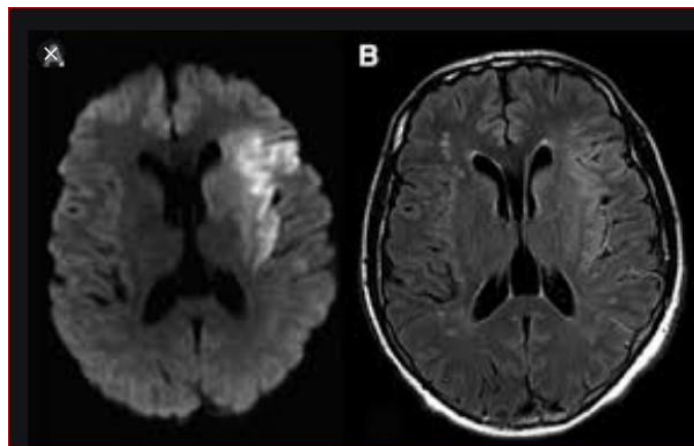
The utilization of diffusion-weighted imaging (DWI) and the apparent diffusion coefficient (ADC) to examine the right middle cerebral artery region. This region exhibits diminished diffusion, attributed to the presence of an acute cerebral infarction.
